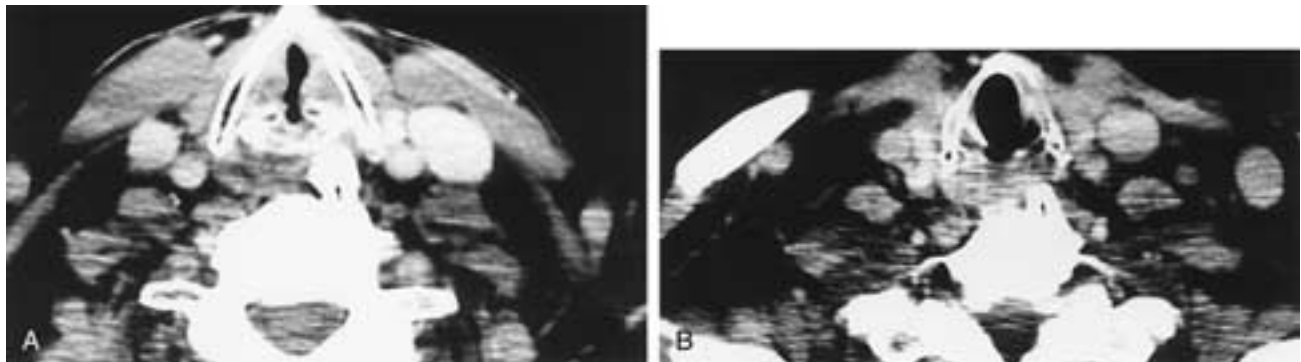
Vocal cord paralysis—enlarged cervical osteophyte. Axial CT scan at the level of the true vocal cord (A) and below (B) identifies osteophytes (arrows) extending into the left tracheoesophageal sulcus.
